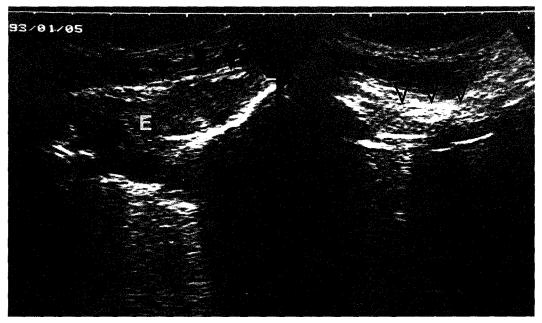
Ultrasound evidence of nonechofree effusion in the patient who had bilateral hip implantation and undergone resection arthroplasty after removal of the right total hip prosthesis due to infection. Ultrasonographic-guided aspiration was performed and 5 ml effusion, which proved on culture to be infected with Staphylococcus aureus, was withdrawn. (E - effusion, black arrows - pseudocapsule. Ultrasound scan of the same patient on the left side showed no evidence of effusion, arrows - thick pseudocapsule formation).
